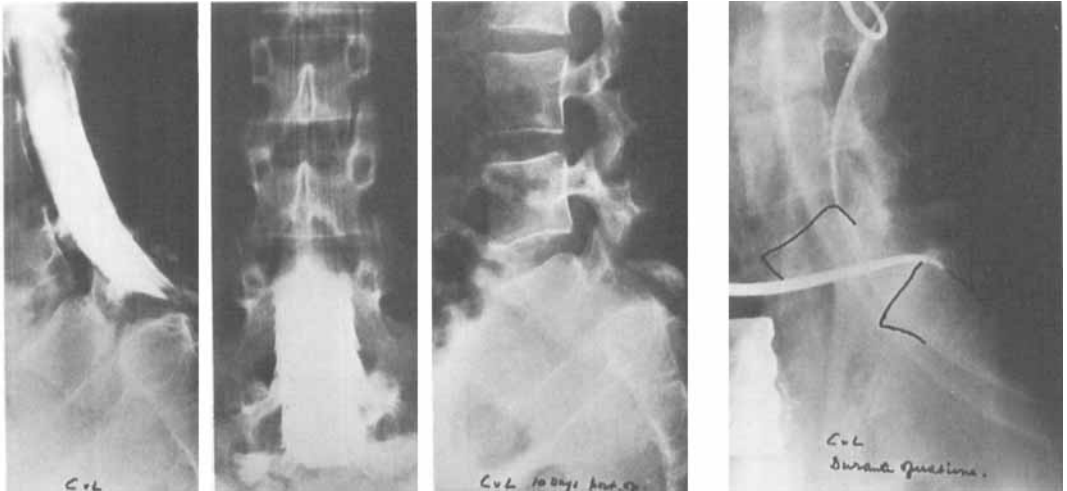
Peroperative X-ray of correction of the spondylolisthesis (right). The disc and the complete anterior part of the annulus have been excised. The patient lies on an inflated pillow, which can be seen as a balloon in this picture. Left: Preoperative and postoperative situation.
